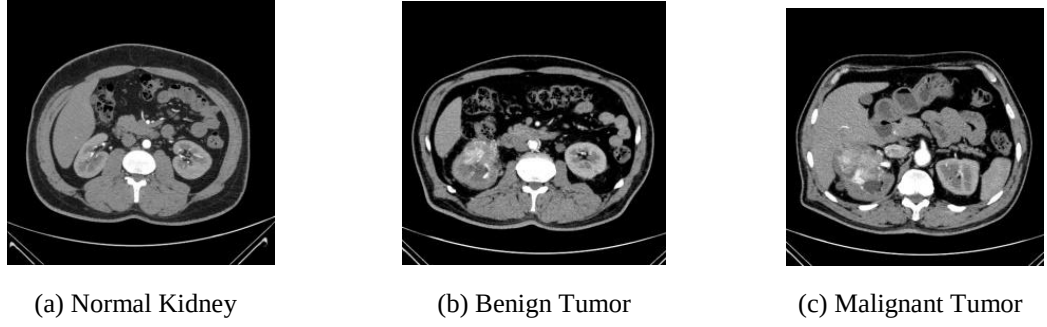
Representative axial CT images from the CT-Kidney dataset.
